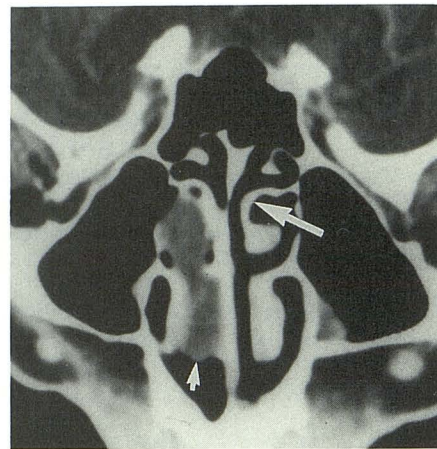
CT scan of right nasal polyps. No bony wall is identified (small arrow) around the mass, helping to distinguish this polyp from a concha bullosa. Large arrow indicates lateral attachment of posterior portion of middle turbinate.
